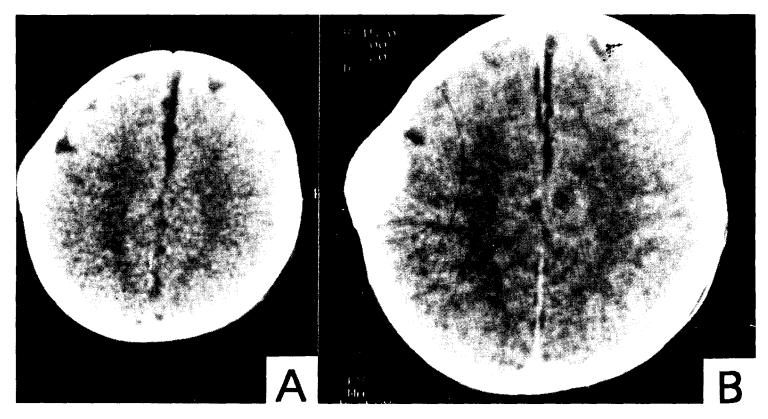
Brain CT. PCT(A) shows a biconvex lesion involving the right parietal bone with homogeneous signal intensity. ECT(B) shows slight signal increase suggestive of minimal contrast enhancement. There was no evidence of brain parenchymal involvement.
